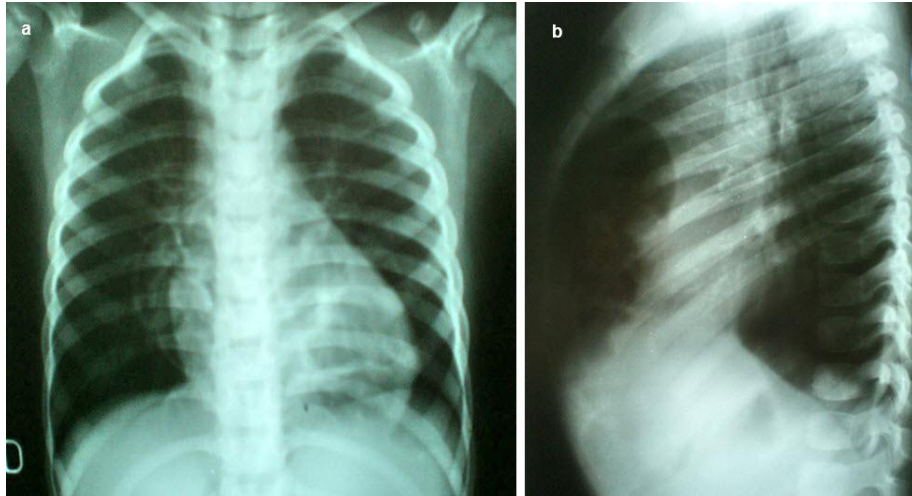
Chest radiograph (AP) shows herniated gut loops in thorax. Figure 1b. Chest radiograph (lateral view) shows herniated gut loops in thorax retrosternally.
